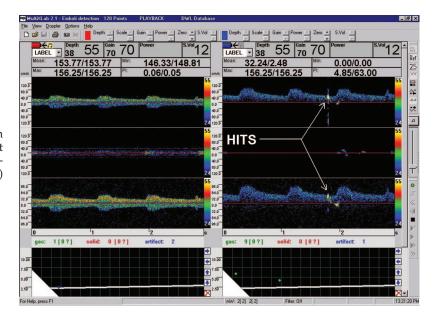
Transcranial Doppler (TCD) screen shows normal pulsation of the right and left middle cerebral arteries. Arrow points at signal (HITS = high intensity transient signal) indicate microemboli passing.
